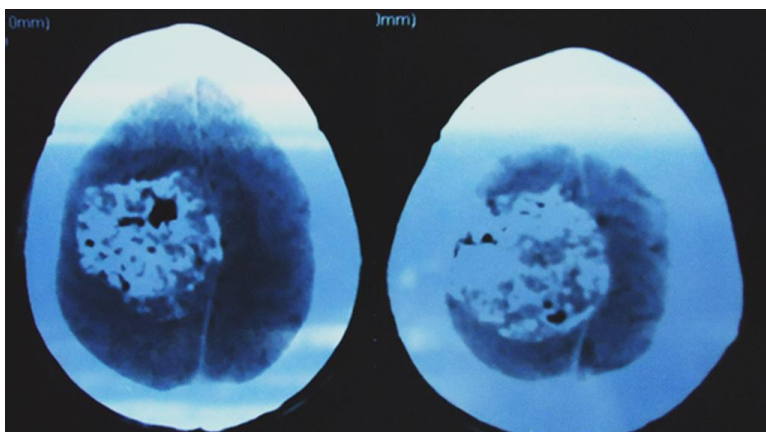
CT image of a parasagittal meningioma in the middle third with calcifications
